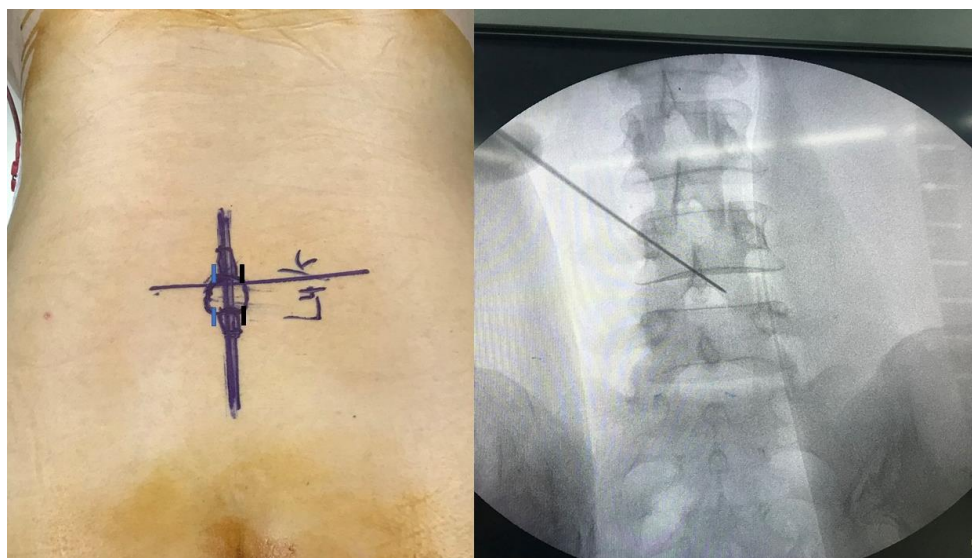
The side of the approach according to MRI study.
